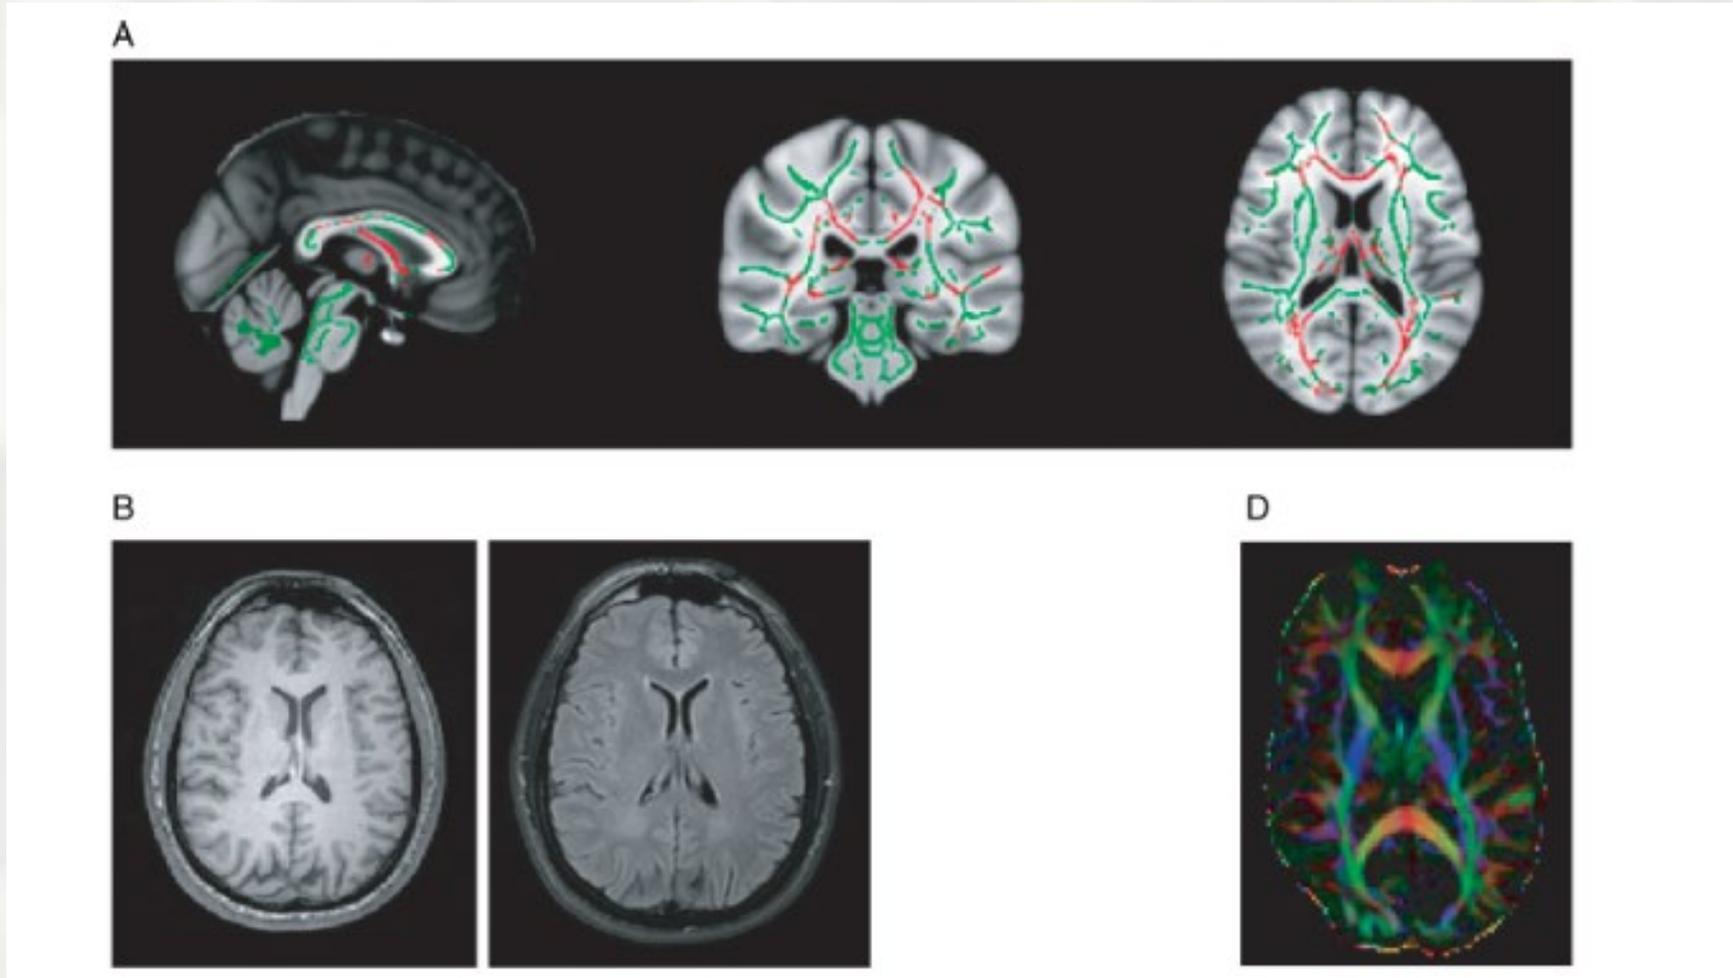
A microbleed is clearly identified on susceptibility weighted MRI (marked with white arrow) but not clearly visible on standard T1 weighted nor fluid-attenuated inversion recovery MRI.
